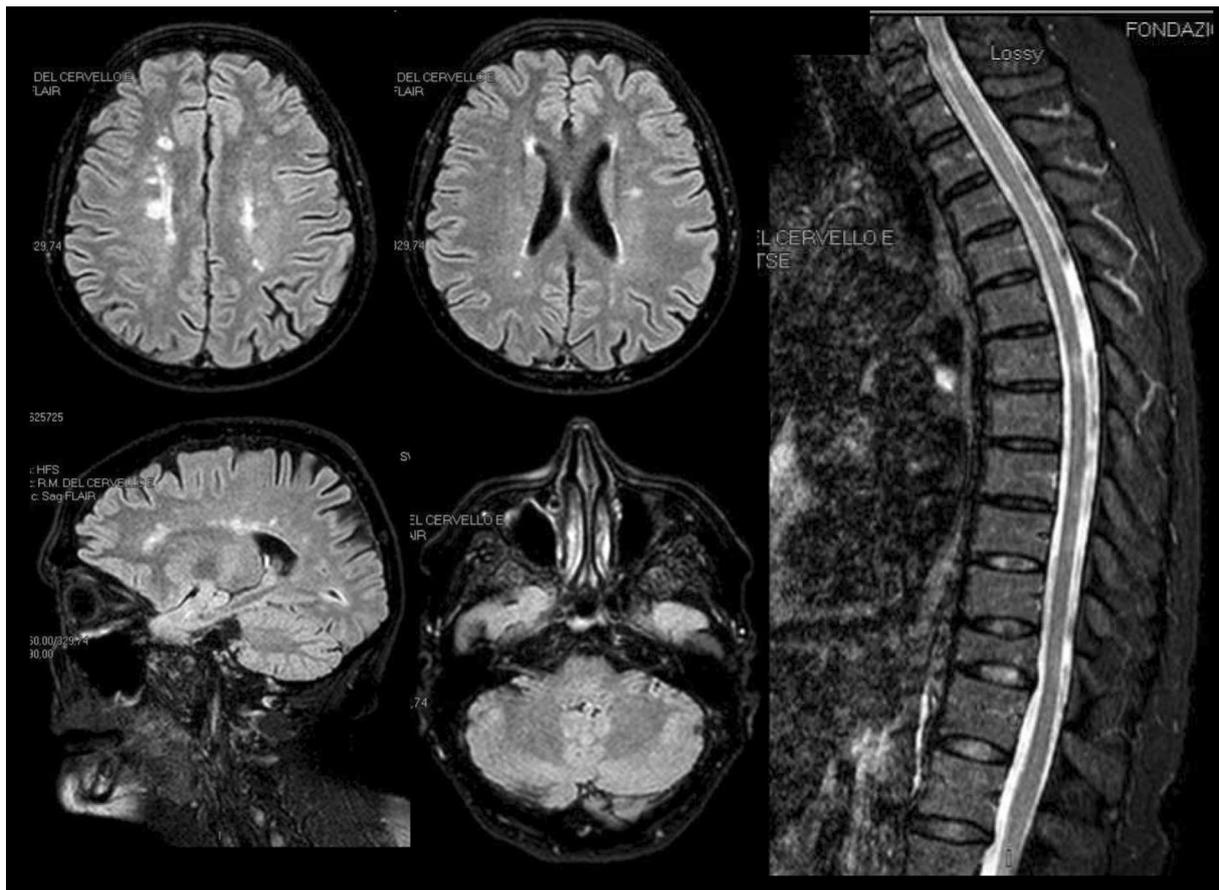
The brain and spinal cord MRI performed after 2 months of interferon- β therapy (May 2019) shows a stability of demyelinating lesions
